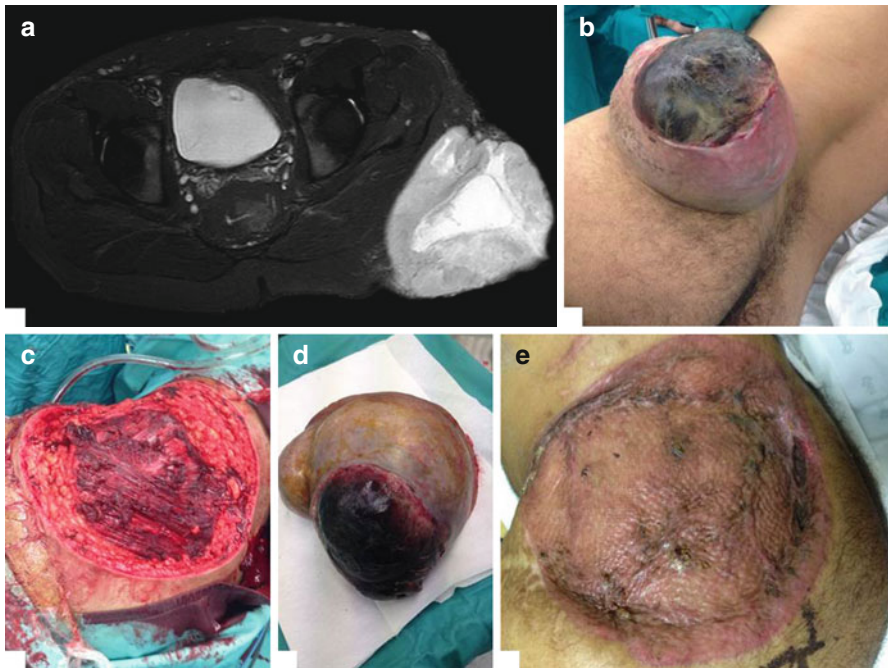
Figure showing a huge ulcerative synovial sarcoma of the pelvis with its MRI imaging (a, b) treated with an en bloc resection (c, d) VAC therapy and skin graft (e)
